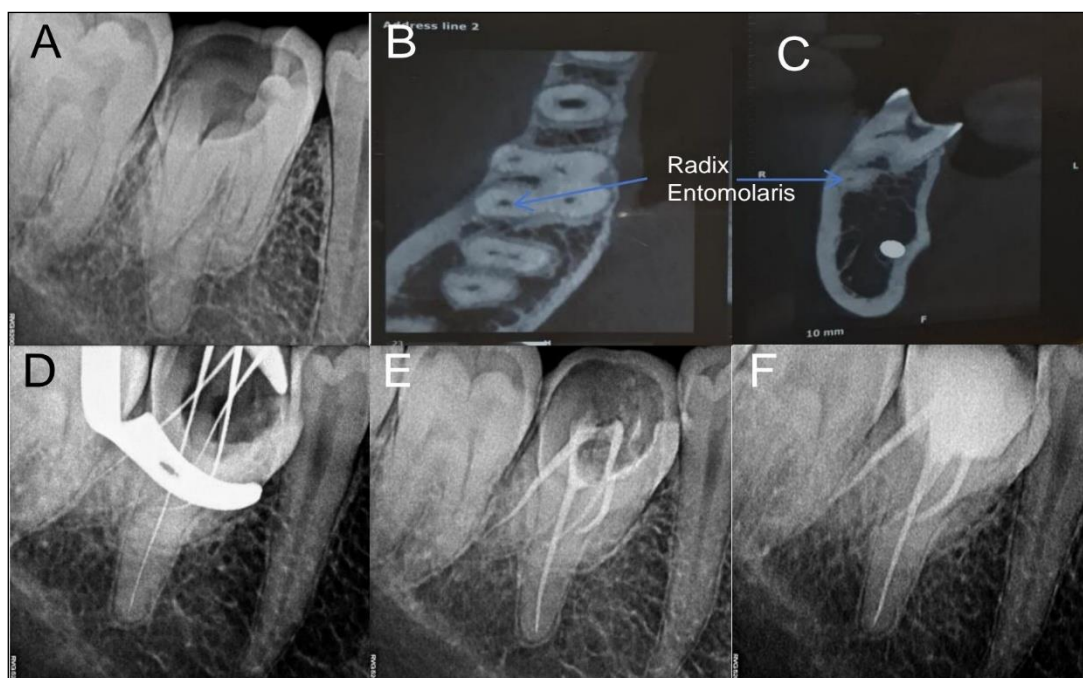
Endodontic Management of the Right Mandibular First Molar (#46) Exhibiting Radix Entomolaris.(A) Preoperative Radiograph. (B, C) CBCT Images Confirming the Presence of a Distolingual Supernumerary Root (Radix Entomolaris). (D) Working Length Determination. (E) Obturation Radiograph. (F) Postoperative Radiograph.
